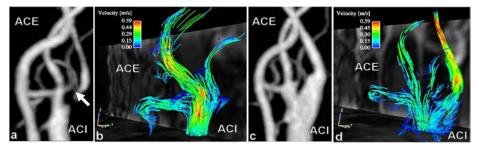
Patient with left-sided pre-occlusive (95%) ICA stenosis. a: CE-MRA revealing a short and highgrade luminal narrowing (arrow) of the ICA with a poststenotic collapse of the vessel lumen. b: corresponding 3D MRI flow visualization. In contrast to external carotid artery (=ACE) branches, no flow can be visualized in the internal carotid artery (=ACI): filling of the vessel lumen=0, helical flow=0) c: CE-MRA after patch angioplasty of the common and internal carotid arteries. d: Restoration of helical flow pattern in the ICA bulb (grading=1) and complete and clear filling of the ICA vessel lumen postoperatively (grading=3). Color coding = absolute mean flow velocities in m/s.
